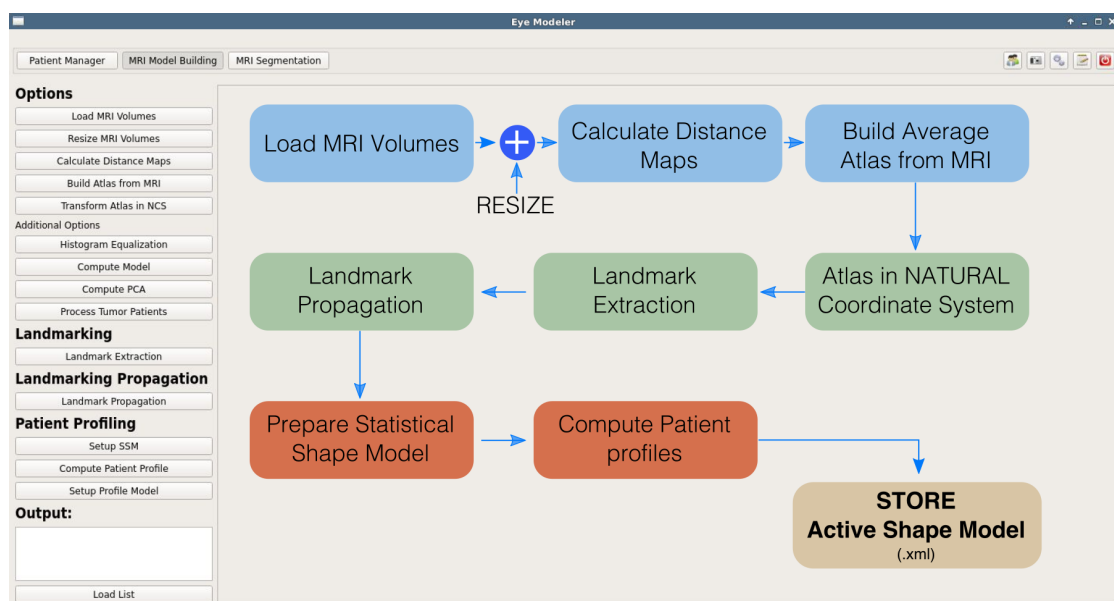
MRI Model Building : In this section we focus on generating the Active Shape Model that best represents the annotated data prior to the MRI segmentation. We created a set of sequential steps for storing intermediate results whenever evaluation is required.
